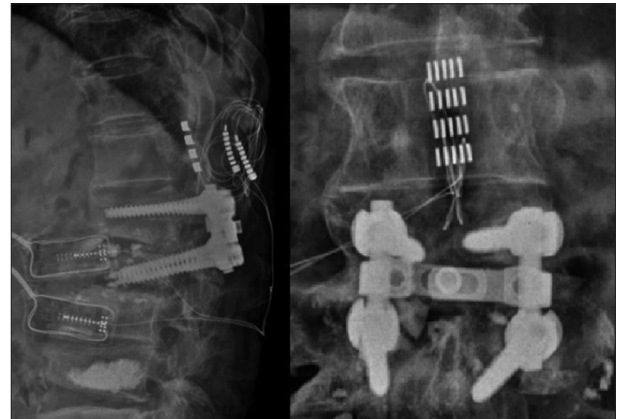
Lateral (left) and AP (right) view x-rays taken after electrode implantation.
